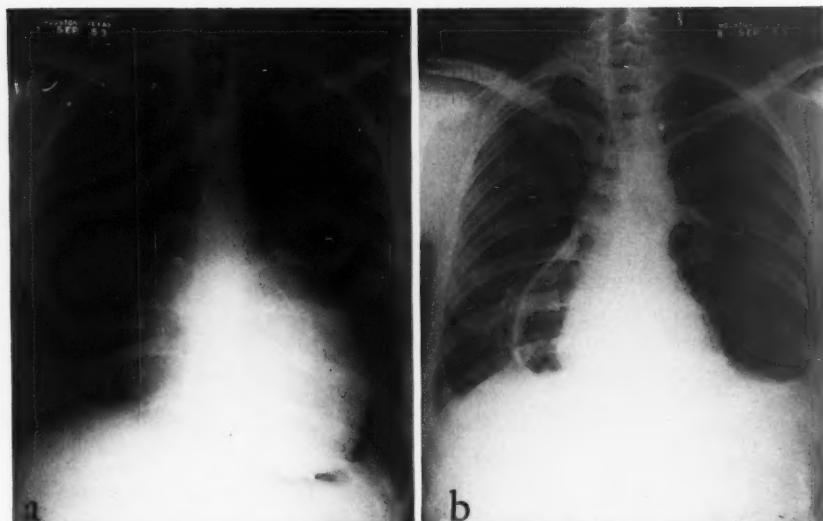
A, chest roentgenogram on admission, showing increase in the size of the cardiac silhouette. B, roentgenogram taken after removal of 1700 cc. of fluid by pericardial aspiration and the injection of 850 cc. of air. The heart appears to be of normal size, but the pericardium is somewhat thickened.
